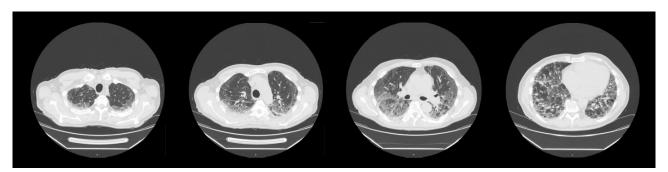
Computed tomography scan of the patient's lungs showing ground-glass opacities predominantly in the peripheral lung regions, with associated thickening of the pulmonary interstitium. Gas trapping is observed in the basal lung areas.
